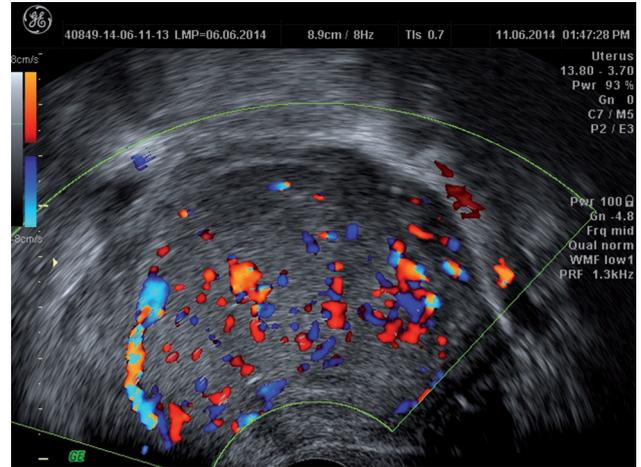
Doppler aspect of uterine PEComa with local invasive potential and local recurrence.
